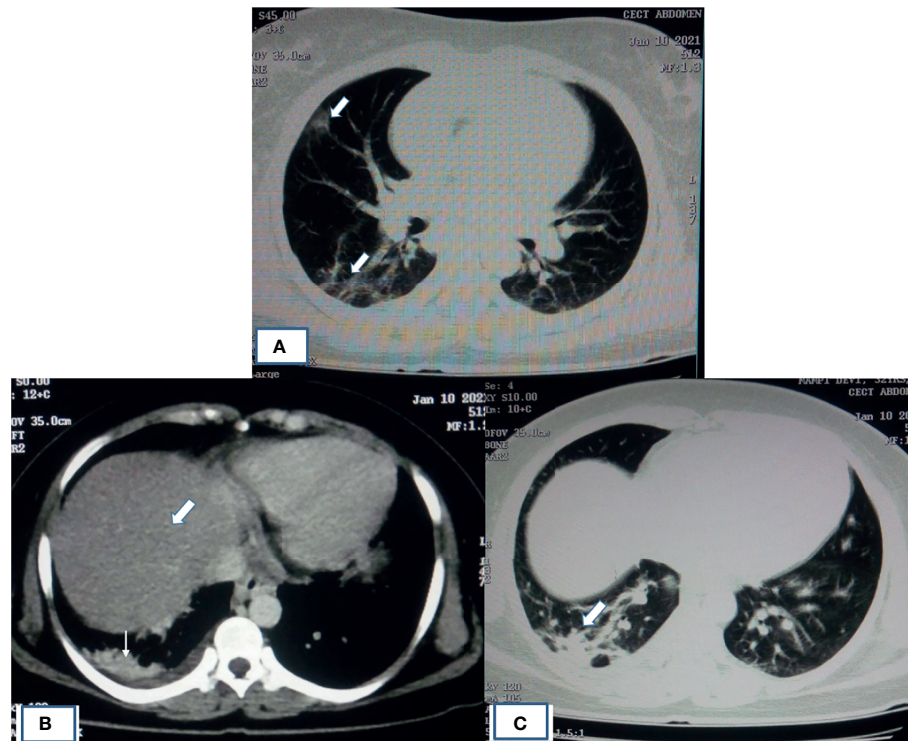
HRCT of patient showing typical imaging manifestations of COVID-19 pneumonia and fatty infiltration of liver. (A) HRCT of chest showing pneumonia in the form of peripheral, multifocal consolidative and ground-glass opacities as indicated by thick white arrow. (B) Mediastinal window image of same COVID-19 patient with altered LFT had shown fatty infiltration of liver (thick white arrow) with opacity in the right lung base (thin white arrow). (C) Corresponding lung window image showing ground-glass haziness of COVID-19 pneumonia (thick white arrow).
